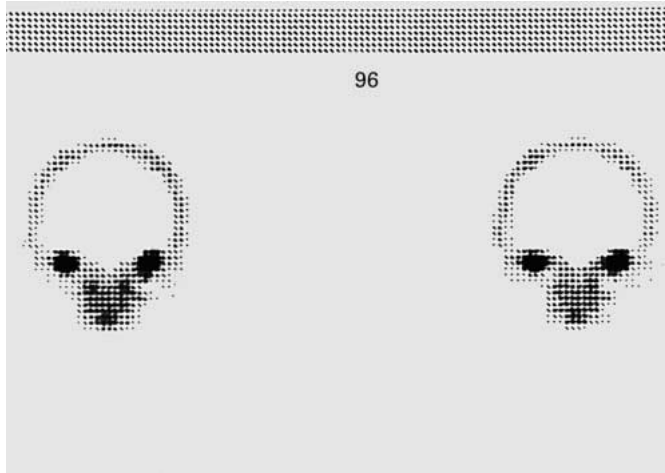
SPECT with 800 MBq of ^{99m}Tc-MDP shows intense radioisotope uptake in both temporal bones in the region of the labyrinthine capsule.
